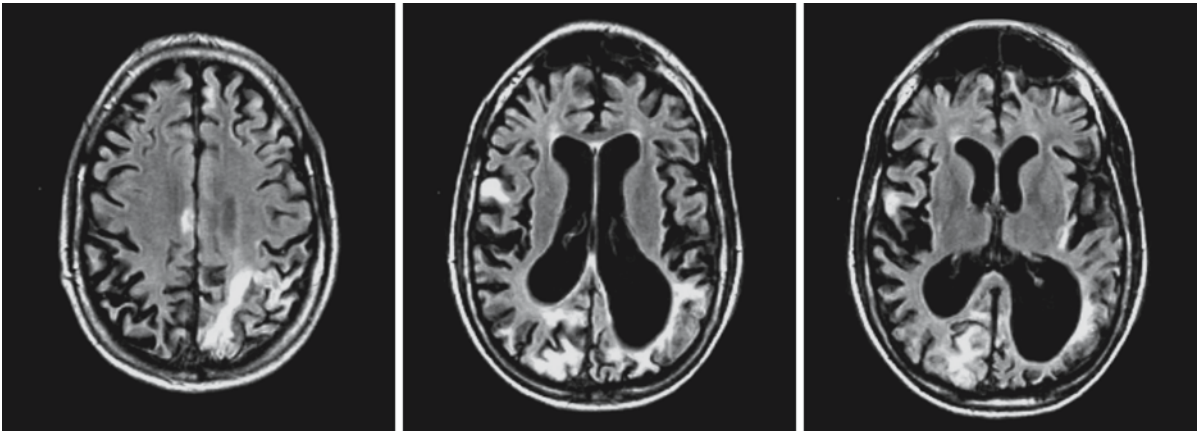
A male patient with MELAS and the 3243 mitochondrial DNA mutation underwent MRI at the ages of 9 years (*first row*), 11 years (*second and third rows*), 12.5 years (*fourth row*), and 15.5 years (*fifth row*). At 9 years, he had seizures and some learning problems, but was otherwise normal. At 11 years, he had seizures and migrainous headaches and was evidently dementing. He had not had any stroke-like episodes. The MRI showed multiple small cortical lesions and generalized cerebral atrophy. The FLAIR images (*third row*) were much better at
